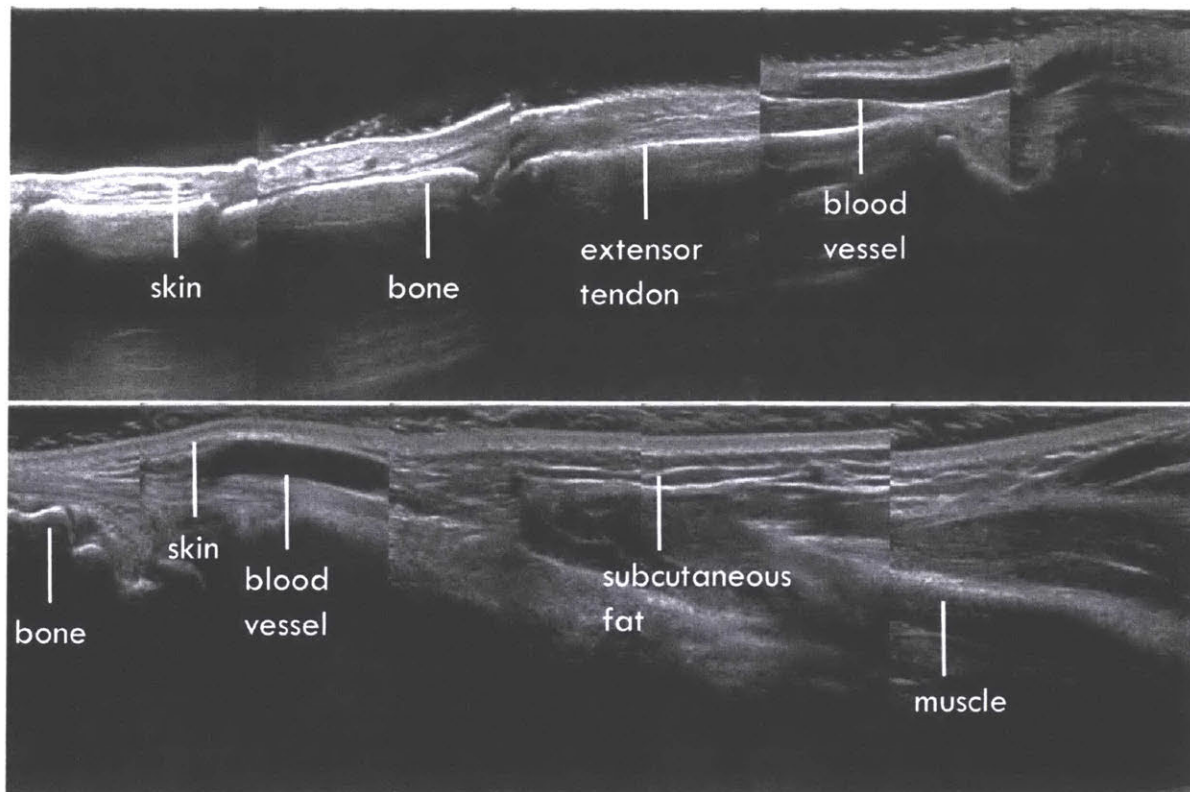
Dorsal ultrasound along fingers (top) and forearm (bottom) showing differing levels of detail
